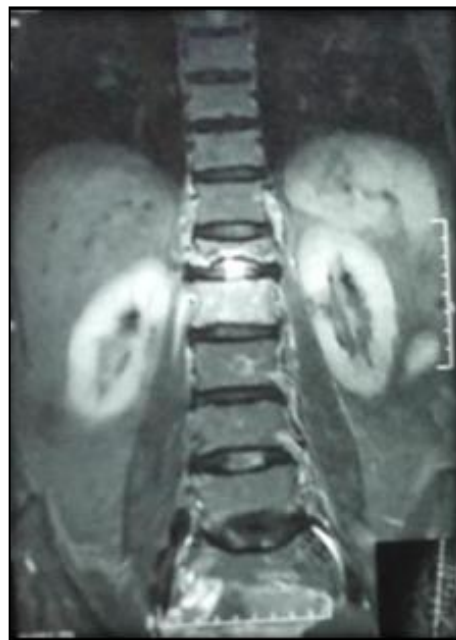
MRI spine showing sclerosis and lytic lesion at T12 vertebrae
